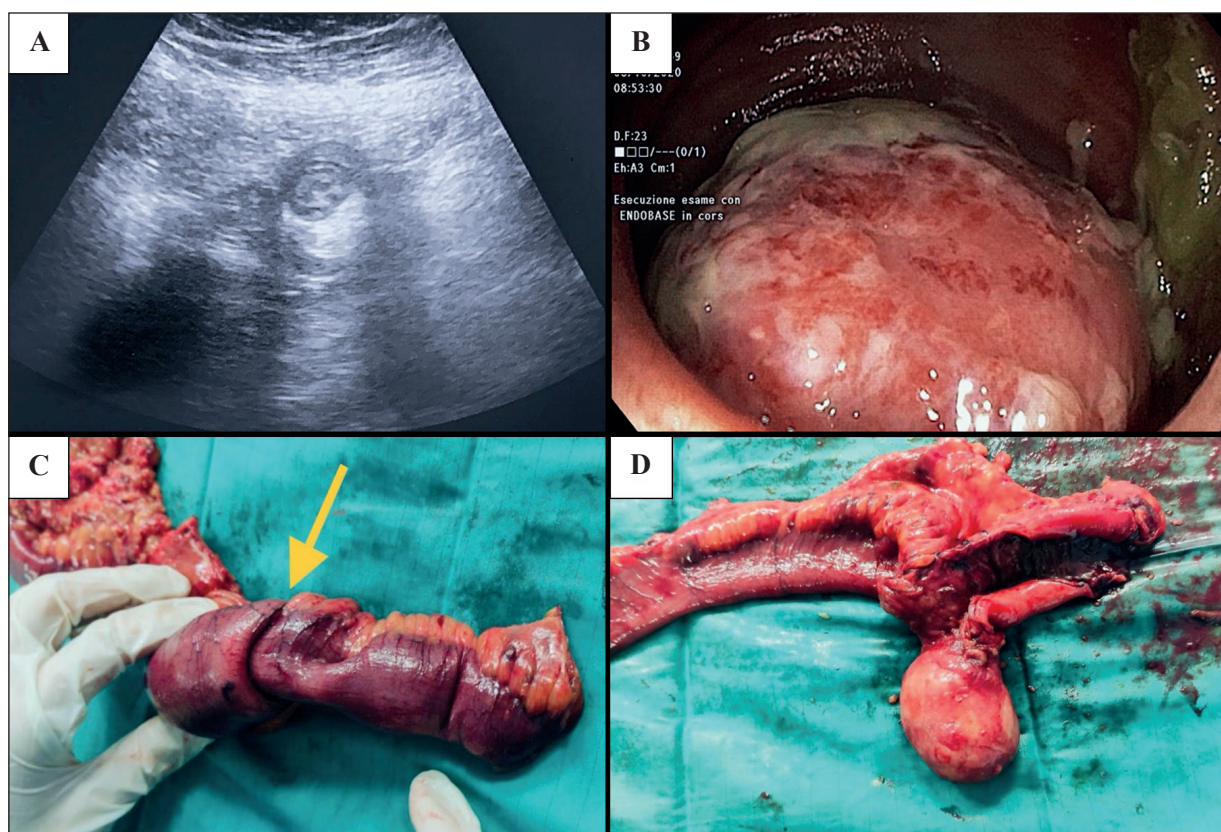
A, Vanek tumor on sonography; B, Vanek tumor on ileoscopy; C, Ileo-ileal intussusception (*arrow*) during surgery; D, Vanek tumor (open surgical finding).
